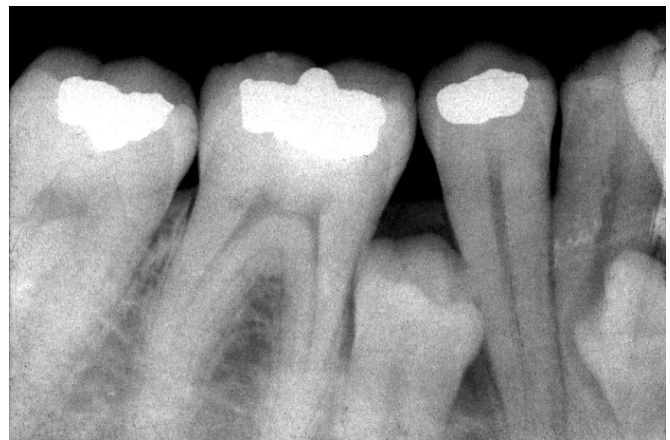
Radiograph of an adolescent in whom the primary second molar exfoliated prematurely due to caries. Without dental intervention to hold the space, the permanent molars drifted mesially, resulting in the second premolar being impacted because its eruptive path was occluded by the earlier-emerging adjacent teeth.
